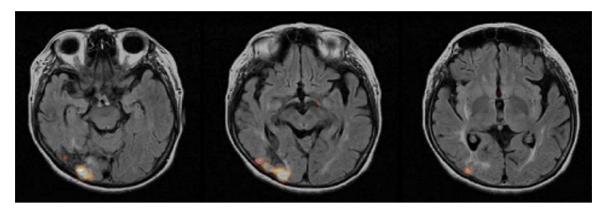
The subtraction SPECT images coregistered with MR images demonstrating a region of increased blood flow in the ventrolateral aspect of the right temporo-occipital junction (middle and inferior occipital, and inferior temporal gyri) adjacent to the cerebromalacia.
